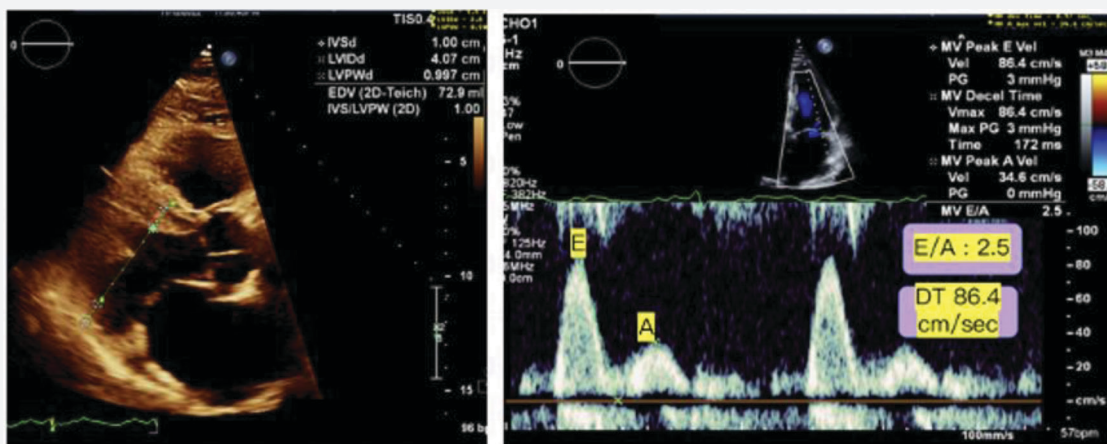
Two-dimensional echocardiogram demonstrating mild concentric left ventricular hypertrophy, thickened mitral and aortic valve leaflets (left image) and E/A ratio of 2.5 consistent with restrictive filling pattern (right image).
